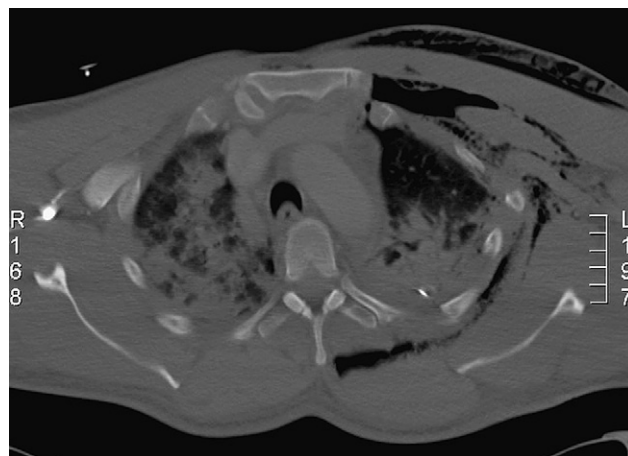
Transverse CT scan of chest showing surgical emphysema and displacement of costo-chondral junction.
